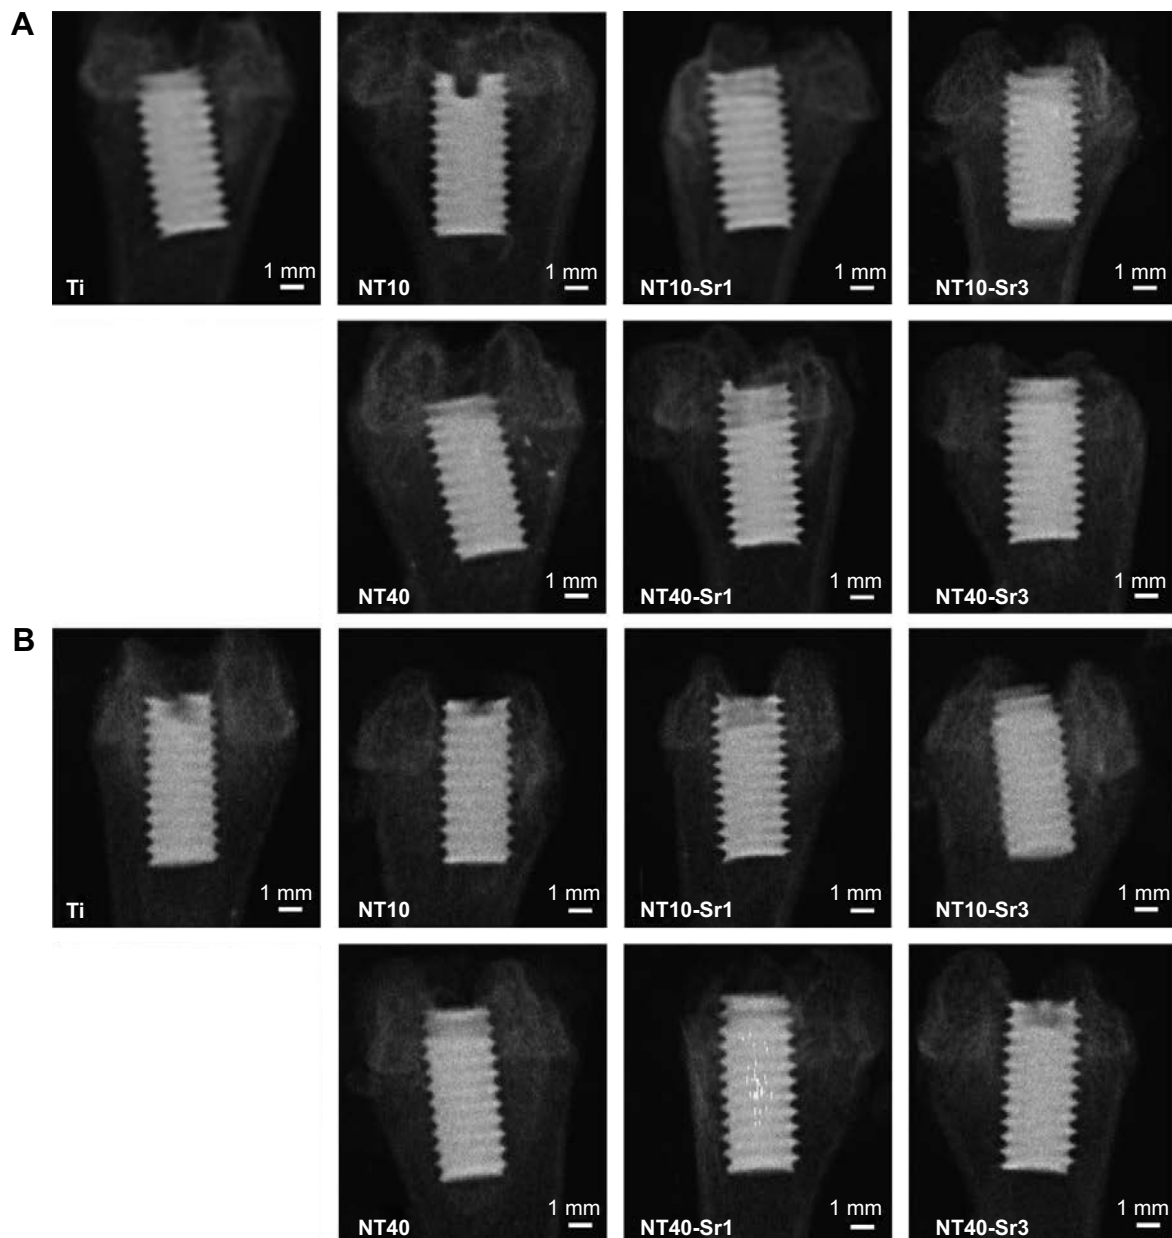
Representative X-ray images of NT, NT-Sr, and Ti control samples 4 weeks (A) and 12 weeks (B) after bony implantation.
